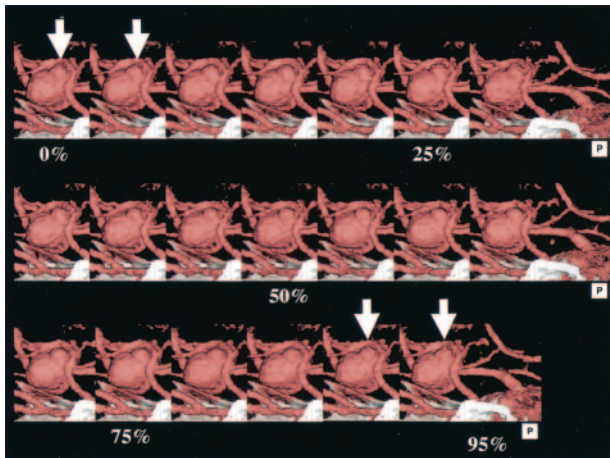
3D-CT angiography of large intracranial aneurysm of the left MCA. The aneurysm with an associated bleb is seen at the origin of the left MCA (arrow).
